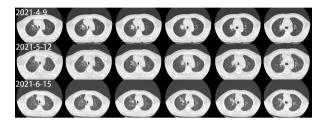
Computed tomography (CT) before treatment (2021.4.9), after (2021.5.12 2021.6.15). No collapse of trachea
